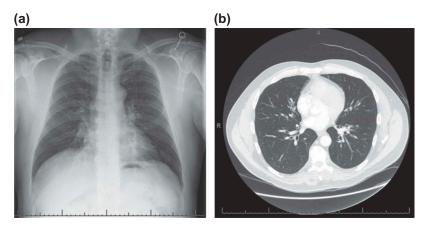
(a) Chest x-ray shows non-enlarged but asymmetric hilar opacities. (b) Axial view demonstrates mild bronchitis with mucoid impaction in several bronchi and several widened bronchi surrounded by inflammation and positive signet ring sign, suggestive of mild bronchiectasis.
